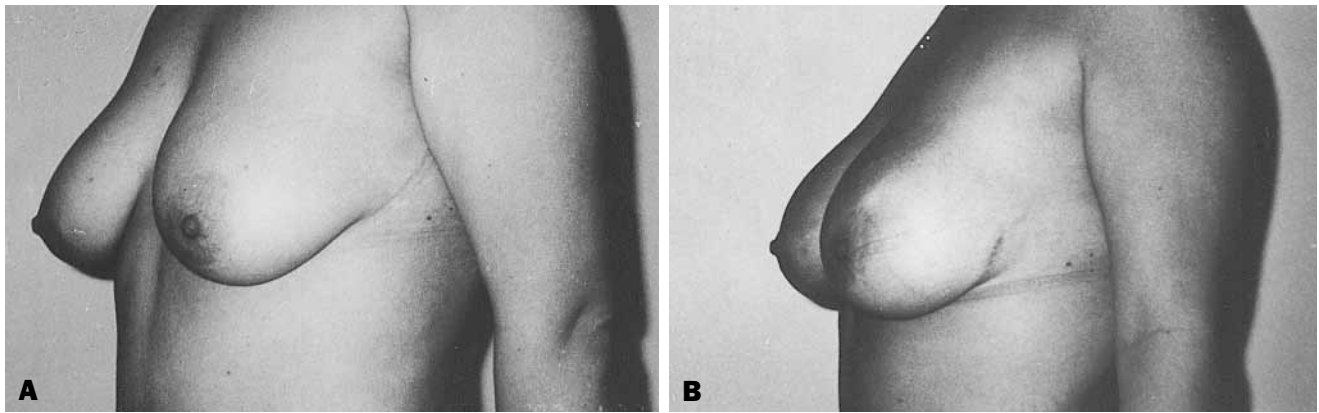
A, Preoperative view of a 30-year-old woman with moderate breast ptosis. B, Postoperative view 3 weeks after ultrasound-assisted lipoplasty subdermal stimulation to allow skin retraction and breast lift.*
